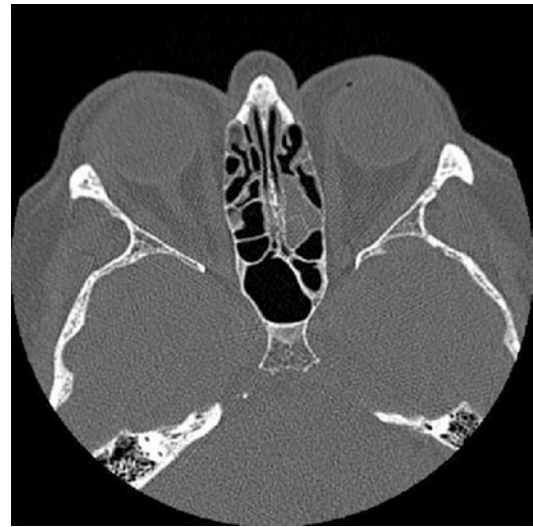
Axial postoperative CT scan demonstrating mucosal thickening in the left ethmoid sinuses
